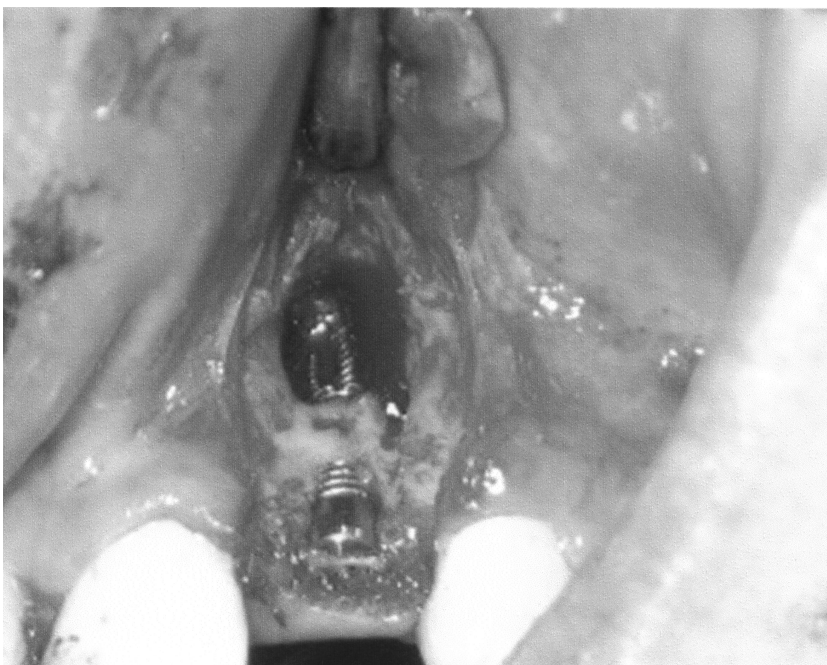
Complete loss of a vestibular alveolar cortical plate with a large periapical defect was noted during surgical debridement.
